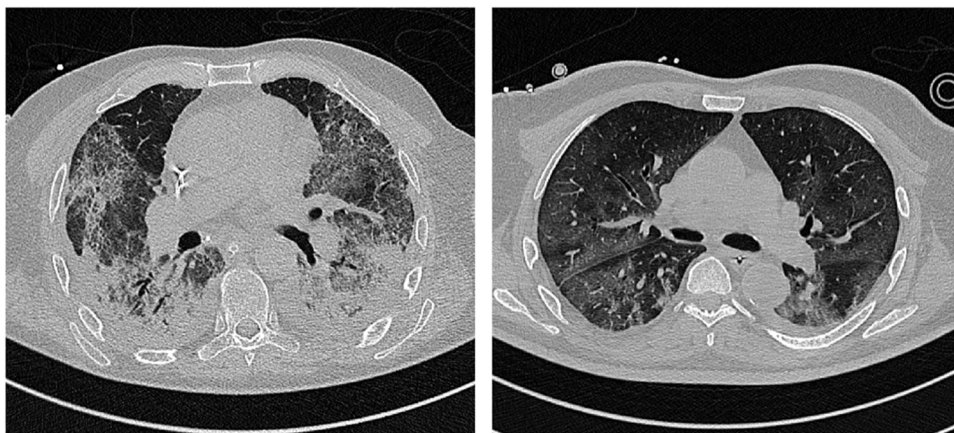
Typical pattern of COVID-19 phenotype 1 and 2. This figure depicts typical patterns of COVID-19 with preserved elastance (phenotype 1, left) and increased elastance (phenotype 2, right) at CT scan.
